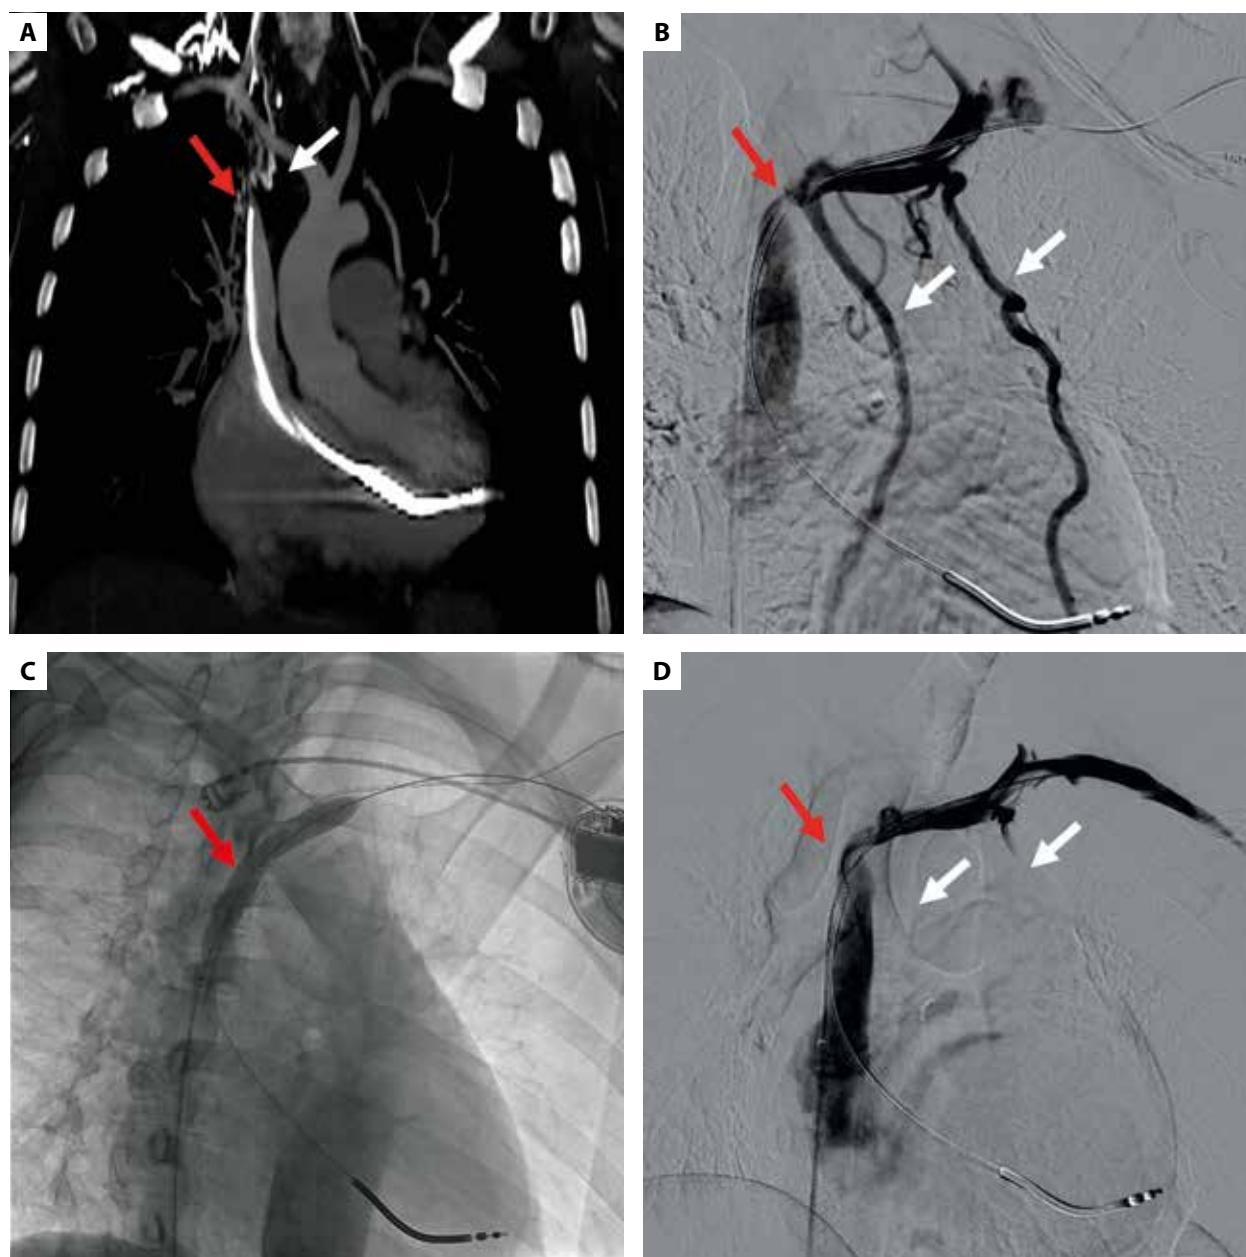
A. Computed tomography angiography showing the obstructed right brachiocephalic vein and subtotal occlusion of the superior vena cava (SVC; red arrow) with visible collateral circulation (white arrow); B. Digital subtraction angiography (DSA) showing critical stenosis of the SVC (red arrow) with visible collateral circulation (white arrows); C. Percutaneous transluminal angioplasty using the EverCross Balloon Catheter (8 × 60 mm, 10 atm, Medtronic); D. Control DSA showing normal outflow from the SVC, with no flow via collateral circulation (white arrows)
